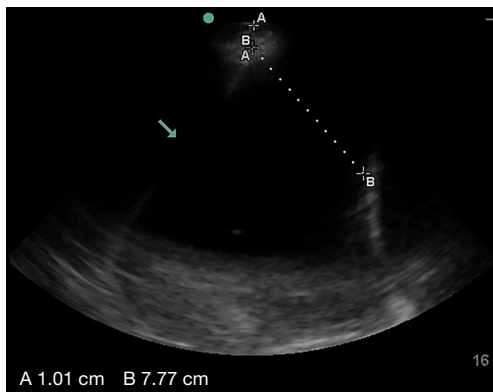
Ultrasound image of confirmed guidewire placement in the pleural space. The green arrow points towards the echogenic wire in the anechoic pleural fluid.
